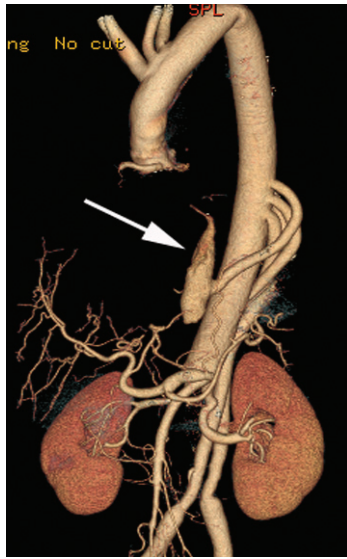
Computed tomography reconstruction of a patient's aorta, which was repaired with a tetrafurcate graft. Neo-intercostal artery is indicated (arrow).
